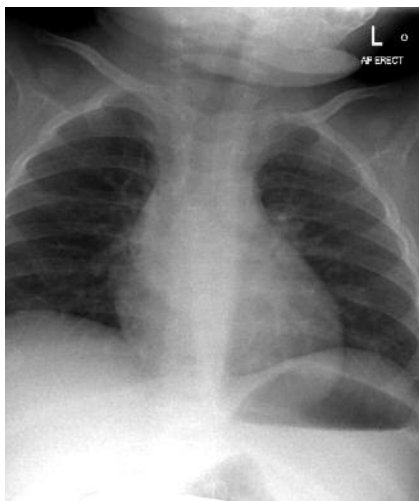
Chest x-ray showing rickets in a dark skinned, fully breastfed infant who presented with bronchiolitis.
